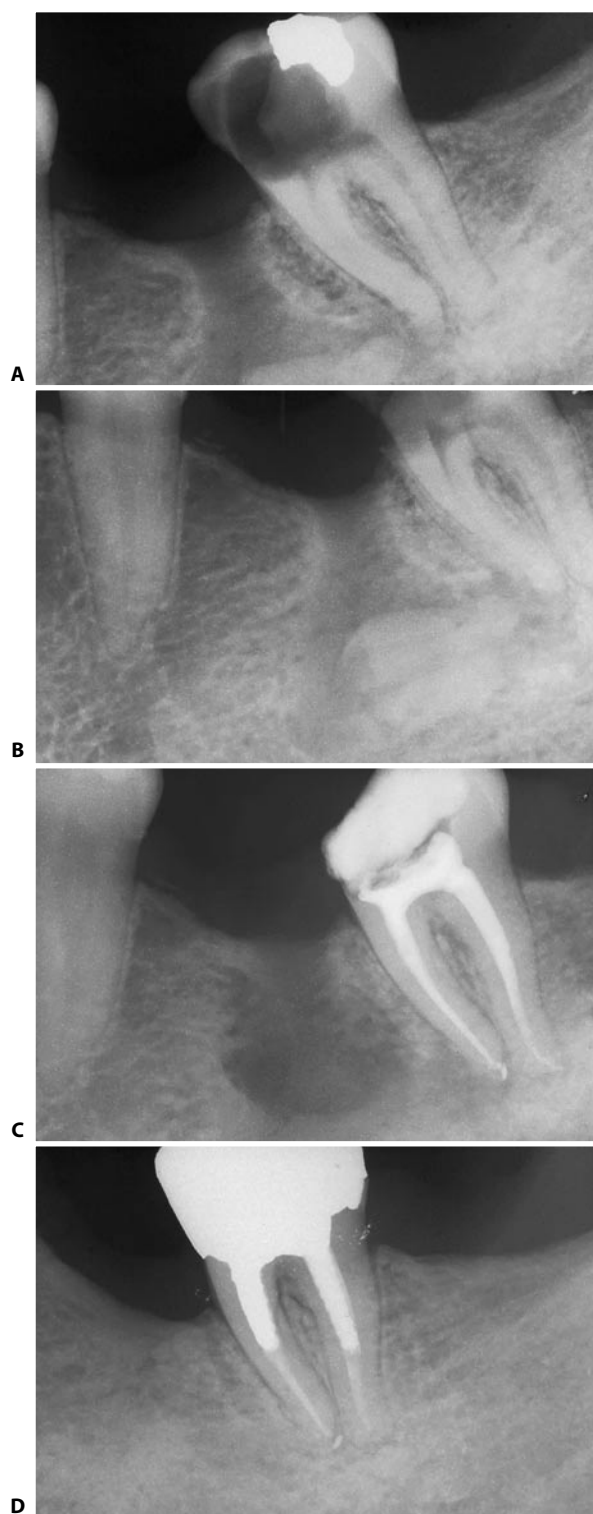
A. The preoperative radiograph of the mandibular second molar shows the presence of a "residual infection" in the zone in which one year prior a necrotic first molar had been extracted. B. A radiograph of the apical area shows that the entire mesial root has fractured during the extraction and then was forgotten in the alveolus. It is evident what this infection is a "residual" of. C. Radiograph following surgical root extraction. D. Healing of the lesion two years later.
